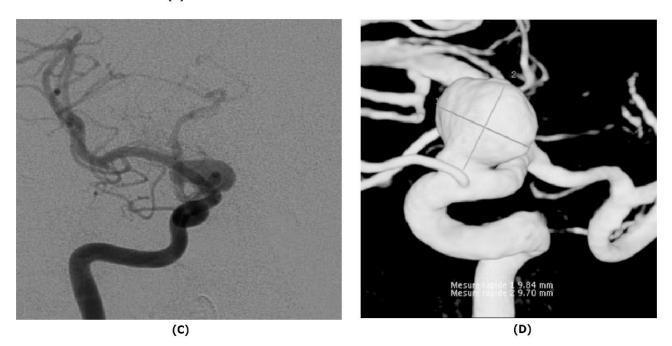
1a (Axial CT image showing subdural hematoma that extends to frontal basal and temporal cortical surfaces), 1b, 1c, 1d (Right internal carotid angiograms lateral and anteroposterior projections and tridimensional reconstruction demonstrating the aneurysm arising from the ophthalmic segment of ICA
